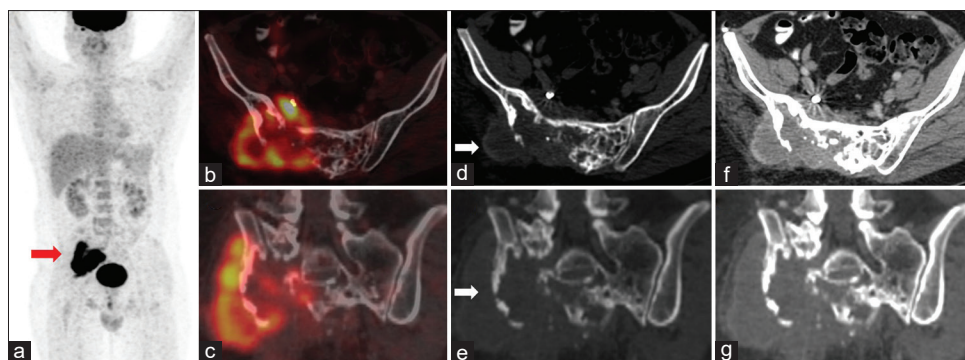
Maximum intensity projection (a- red arrow) shows intense uptake in right sacroiliac joint region. Fused positron emission tomography/computed tomography images (b and c) show intense heterogeneous FDG uptake in right sacroiliac joint which corresponds to destructive soft-tissue mass extending into neural foramina with cortical destruction and expansion seen on transaxial and coronal computed tomography images (d-g)
